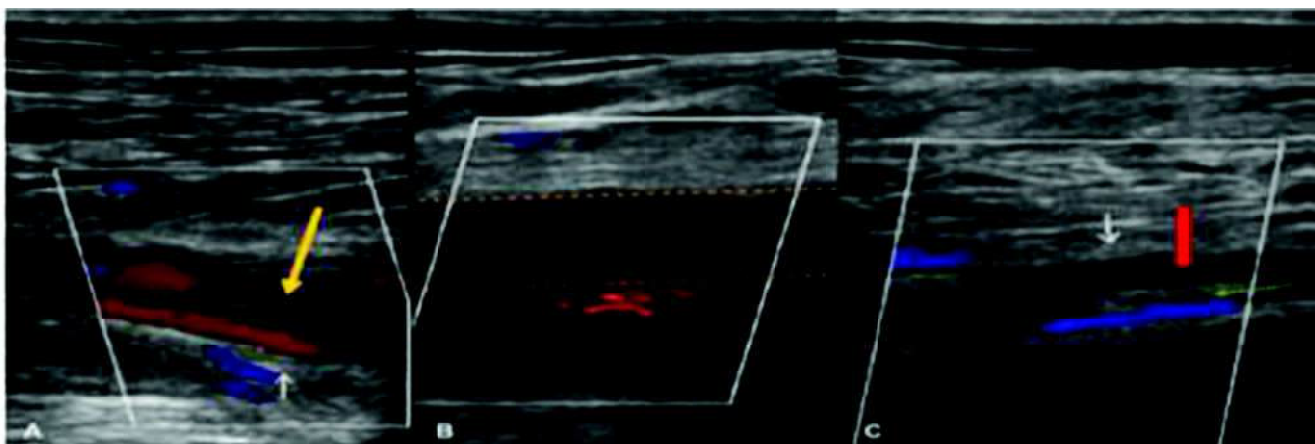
Doppler venous ultrasound demonstrating thromboses in the right (A) femoral, (B) popliteal, and (C) peroneal veins.
